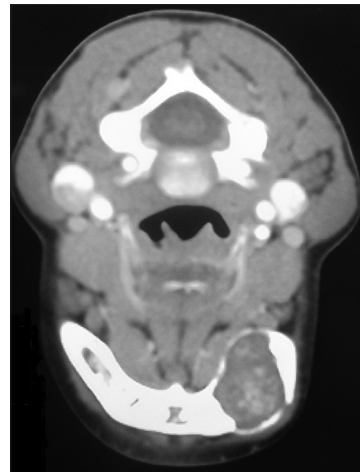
Unilocular lesion in the left mandibular body, 2.5 x 3 cm in size, with well-defined border in axial CT scan
